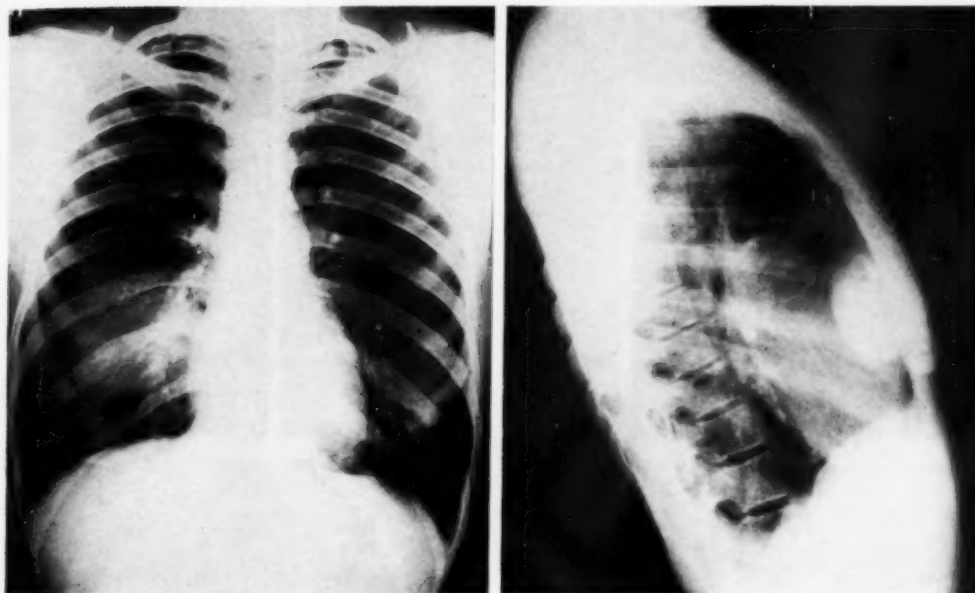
Case IV. Benign localized fibrous mesothelioma arising from visceral pleura over the inferior anterior surface of the upper lobe of the right lung. The roentgenographic appearance is not unlike that often observed in masses arising in the chest wall and projecting into the thorax.
